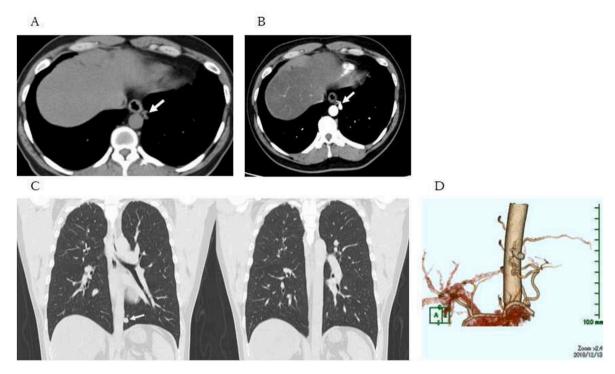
(A) Computed tomography image showing a nodule in the left lower lobe. (B) Contrast-enhanced computed tomography showing inflow of contrast medium into the nodule and (C) the connection between the nodules and pulmonary artery. (D) Computed tomography angiography showing the aneurysm associated with the left inferior phrenic artery-to-left pulmonary artery fistula.
